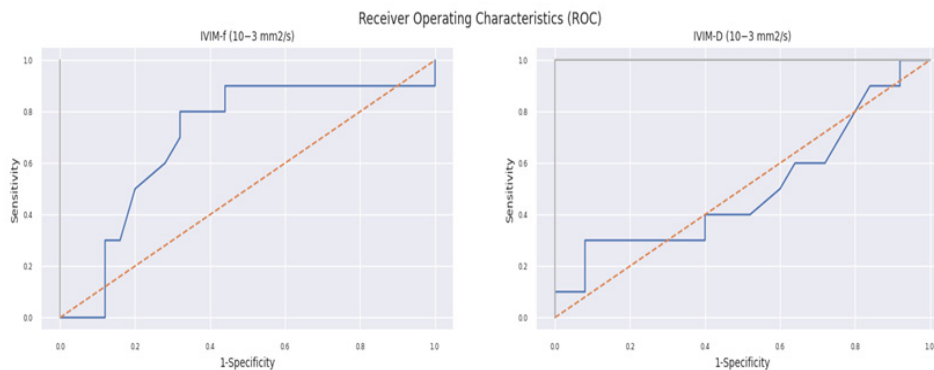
Receiver Operating Characteristics (ROC) of Non-Predictive MRI Parameters.
